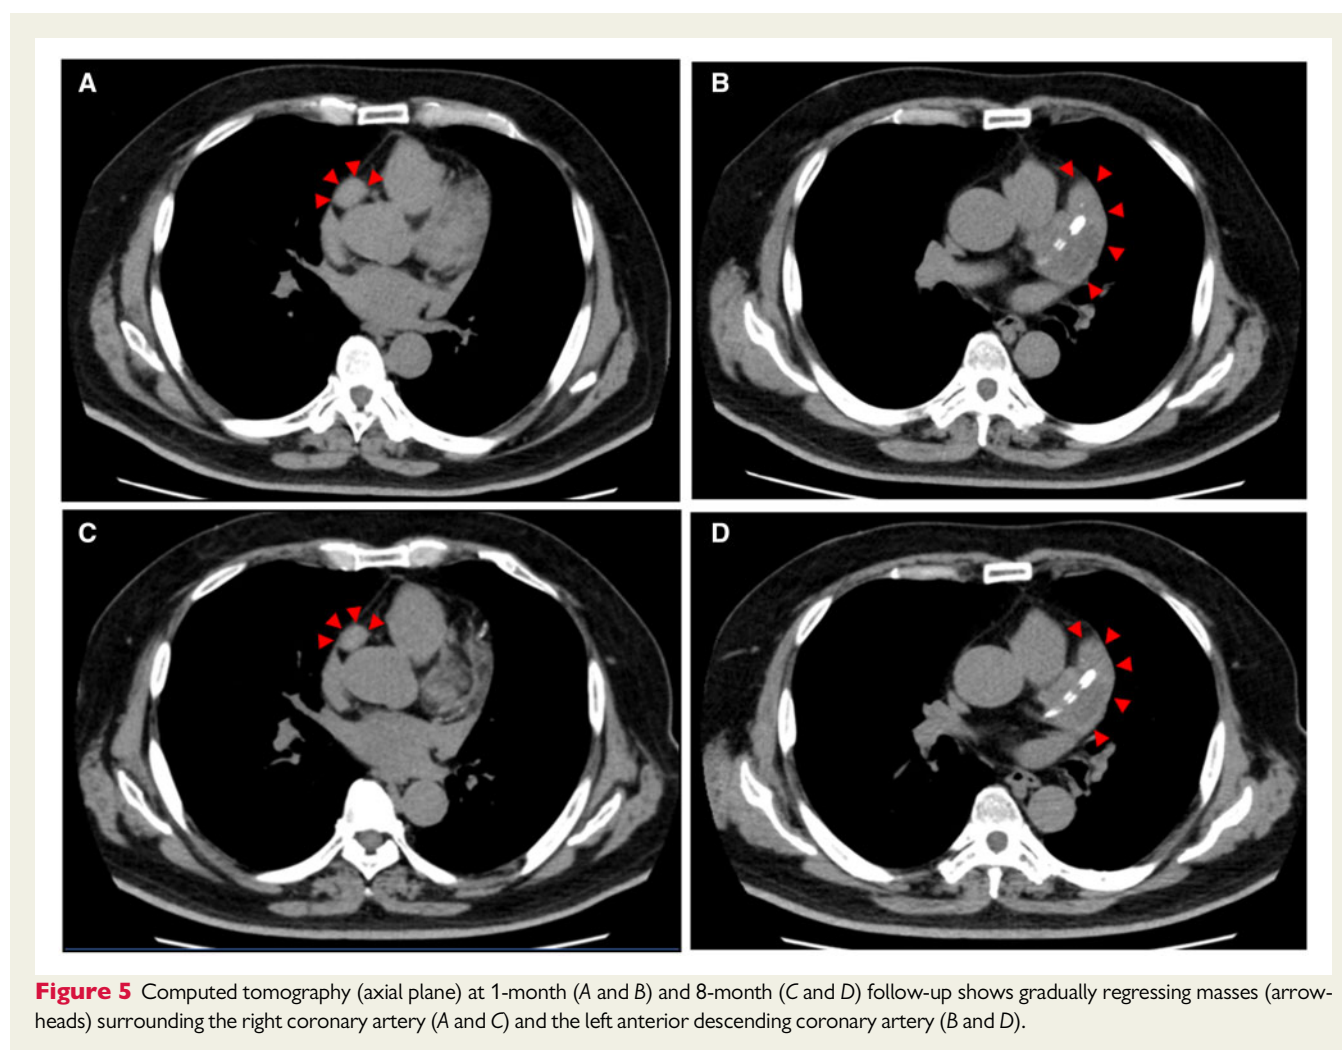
Computed tomography (axial plane) at 1-month (A and B) and 8-month (C and D) follow-up shows gradually regressing masses (arrowheads) surrounding the right coronary artery (A and C) and the left anterior descending coronary artery (B and D).
